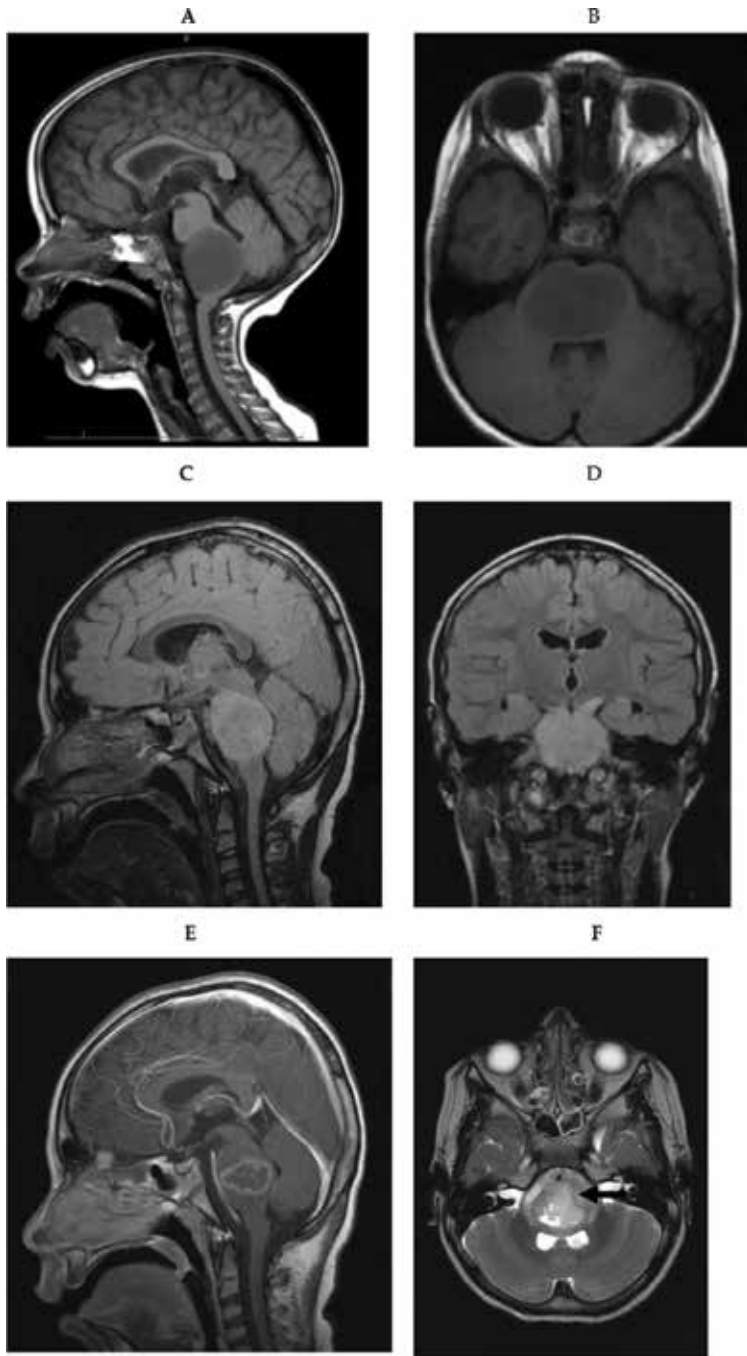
T1-weighted pre-contrast sagittal (A) and axial (B) MRI pictures showing poorly marginated, expansile and hypointense pontine mass. It is hyperintense on T2-weighted/FLAIR sagittal (C) and coronal (D) images. (E) There is minimal post-gadolinium enhancement. (F) Basilar artery encasement by DIPG (black arrow).
